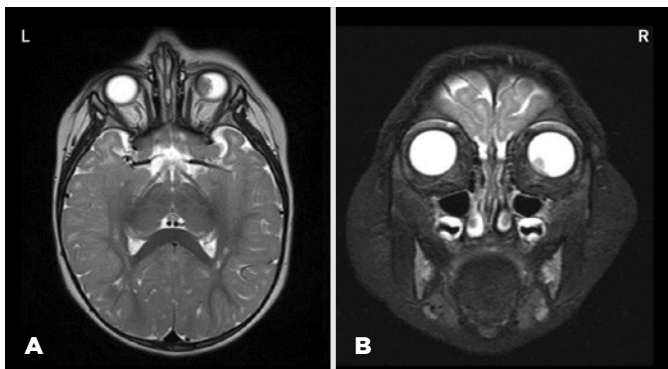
At presentation: axial [left (L)] and coronal [right (R)] magnetic resonance imaging (MRI) scan showing a hypointense mass in the left eye measuring 10.0 x 10.0 x 5.60 mm and vitreous seeding measuring 4.0 x 2.6 mm not involving the optic nerve.
